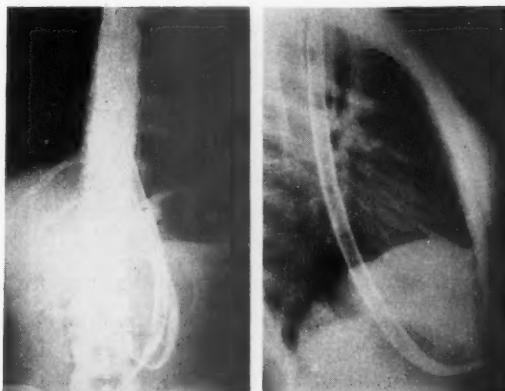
Case 7.—Functional hiatal stenosis. Achalasia. *a*. Roentgenogram showing 2 short cannulated bougies (No. 30) in the hiatal esophagus. Patient swallowed fluids and purees normally with bougies in position. *b*. Roentgenogram showing size 40 cannulated bougie introduced through the hiatal esophagus. The bougie was introduced perorally through a previously swallowed string. The upper opening in the cannulated bougie is below the suprasternal notch, the lower opening is in the stomach. The bougie was suspended in this position by a string in the pharynx attached to an Equen "gadget" on an artificial denture.
